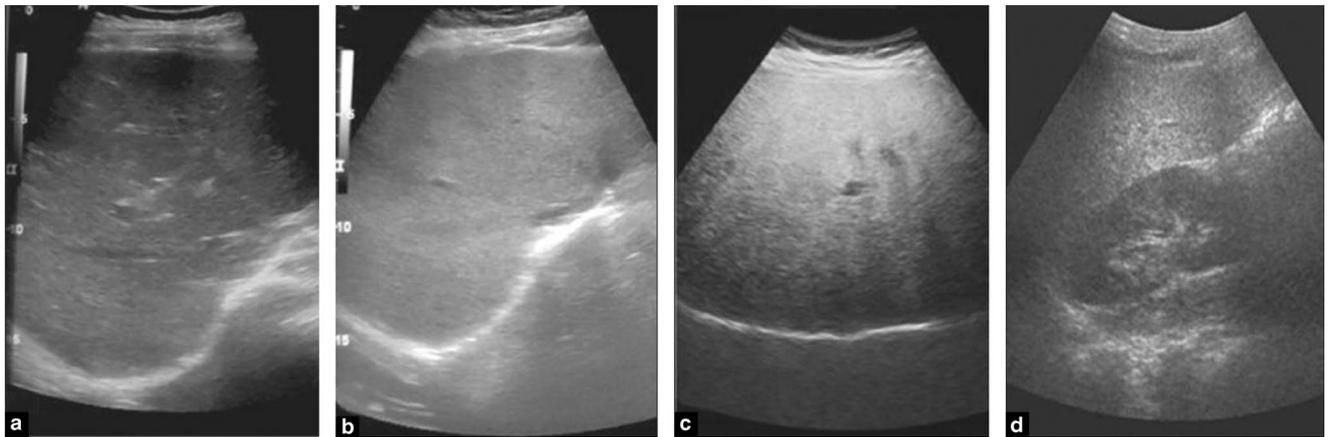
Ultrasound image shows different grades of fatty liver. (a) Normal liver echogenicity—Steatosis, <5%. (b) Grade 1 fatty liver with increased liver echogenicity—Steatosis 5, 33%. (c) Grade 2 fatty liver with the echogenic liver obscuring the echogenic walls of the portal venous branches—Steatosis, 33–66%. (d) Grade 3 fatty liver in which the diaphragmatic outline is obscured—Steatosis, >66%
